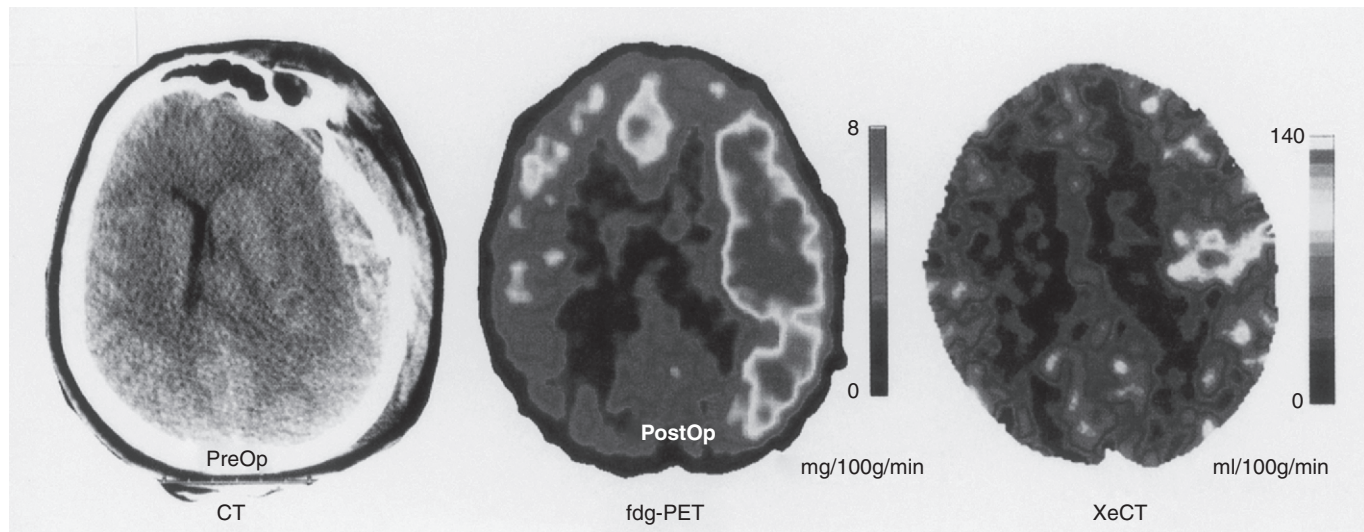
CT image (left) of an acute subdural hematoma with mass effect that was treated with surgical evacuation. ^{18}F -fluorodeoxyglucose positron emission tomographic (PET) map (center) obtained at 5 days after surgery shows marked local increases in cerebral glucose utilization in the brain regions underlying the hematoma. Stable Xe-enhanced CT CBF map also obtained at 5 days after surgery shows increased CBF in the same region, indicating that the increase in glucose utilization is not the result of hypoperfusion. This phenomenon, termed *hyperglycolysis*, is suggested to represent increased glucose utilization by astrocytes coupled to glutamate uptake and other mediator-driven processes. This highlights the complex regional metabolic demands of the traumatically injured brain.
